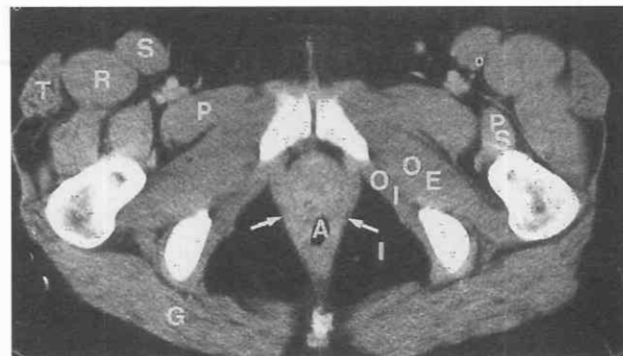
Normal anatomy. CT scan through the symphysis pubis shows the obturator internus muscle (OI) and obturator externus muscle (OE) on either side of the obturator foramen and the psoas muscle (PS) inserting on the lesser trochanter of the femur. Other muscles are the pectineus (P), sartorius (S), rectus femoris (R), tensor fasciae latae (T), and gluteus maximus (G) muscles. The pelvic diaphragm (arrows) separates the anus (A) from the ischiorectal fossae (I).
